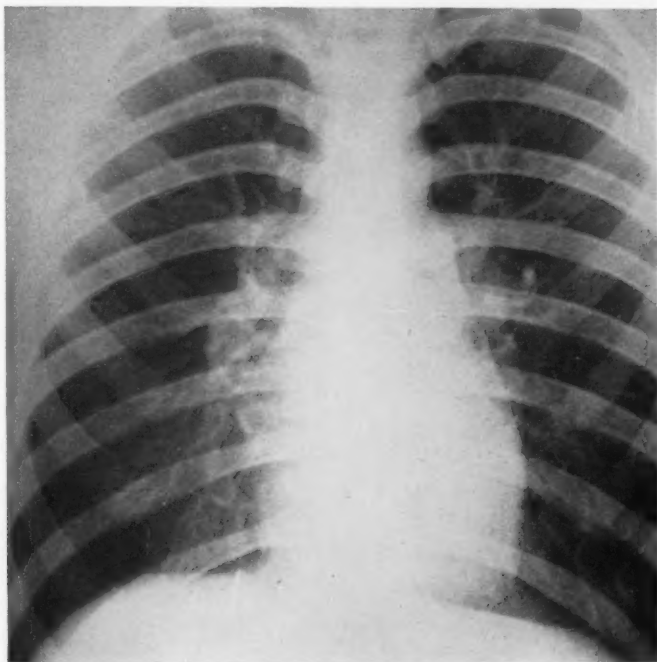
Postero-anterior roentgenogram revealing a tack in the right lower lobe of the lung immediately adjacent to the right heart border just beyond the crest of the diaphragm.
